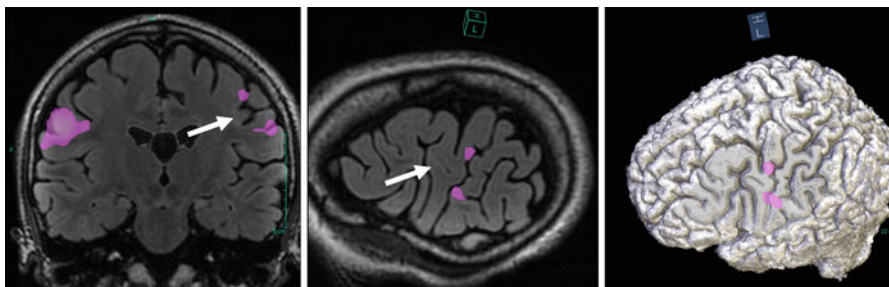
Patient with a left precentral focal cortical dysplasia within the lateral primary motor cortex (arrow). The patient is asked to perform lip movements during a functional MRI acquisition. In comparison to the normal right side, the response near the lesion is less significant and fragmented on both side of the lesion
